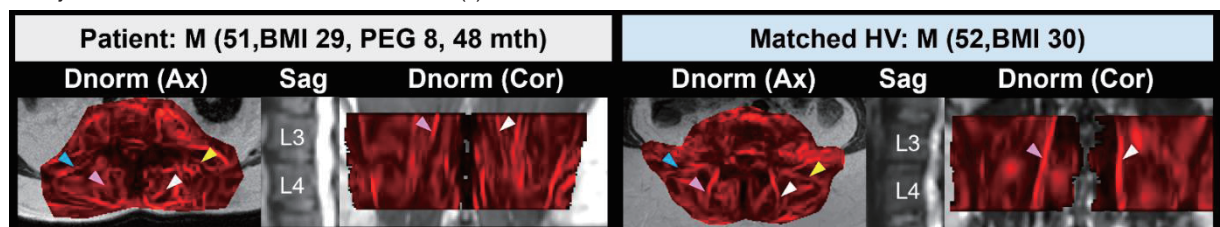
Example Dnorm map comparison between a CLBP patient (Male, age 51, BMI 29, PEG 8, pain duration 48 months) and a matched healthy volunteer (Male, age 52, BMI 30). Axial (Ax) and coronal (Cor) views at L3–L4 are shown with sagittal (Sag) reference images. The patient shows low intensity at L4 ES-M interface on Dnorm. Arrows indicate QL-ES (blue: right, yellow: left) and ES-M (pink: right, white: left) interfaces. Dnorm maps are overlaid on T2-weighted (Ax) and MRE magnitude (Cor) images.
